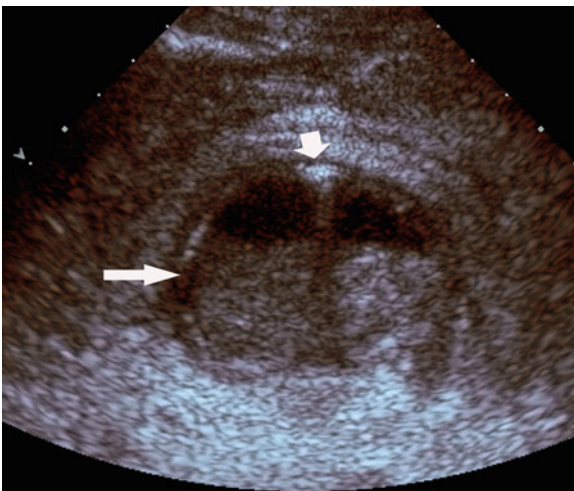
Gas-forming periappendiceal abscess. Grayscale transverse sonogram of right lower quadrant demonstrates complex fluid collection (*long arrow*); note high-amplitude gas casting acoustic shadow within nondependent portion of abscess (*short arrow*). Appearance is nonspecific and could represent abscess from another etiology, but at surgery necrotic appendix was identified at cecal tip as cause for abscess
